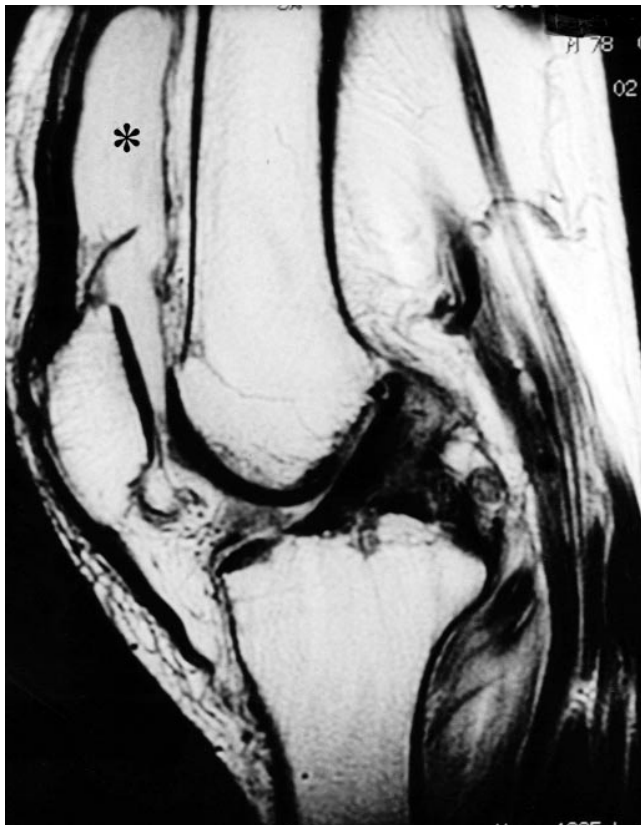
Sagittal T2 weighted MRI scan of the right knee before synovial rupture shows massive joint effusion in the suprapatellar pouch (asterisk).
